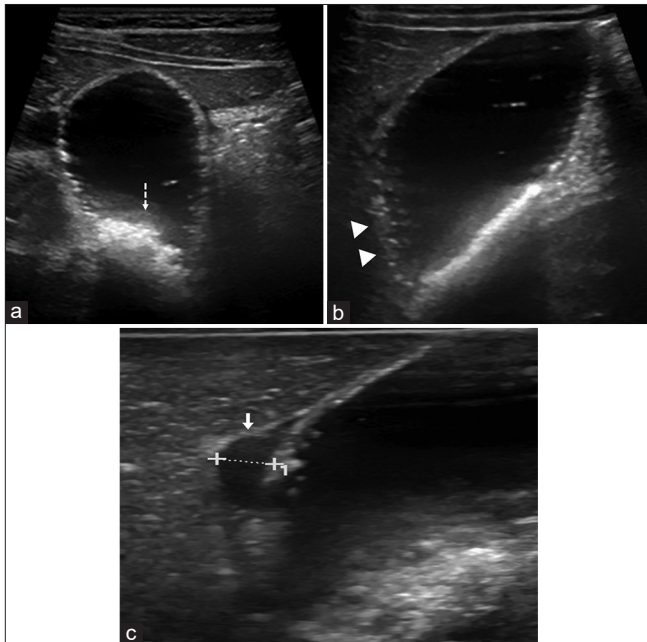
(a) Ultrasound image showing biliary sludge and pseudolithiasis formation (dashed arrow). (b and c) In addition, ultrasound images revealed (b) thickening of the gallbladder wall (arrowheads), (c) pericholecystic fluid (arrow) and probe tenderness, consistent with acute cholecystitis
